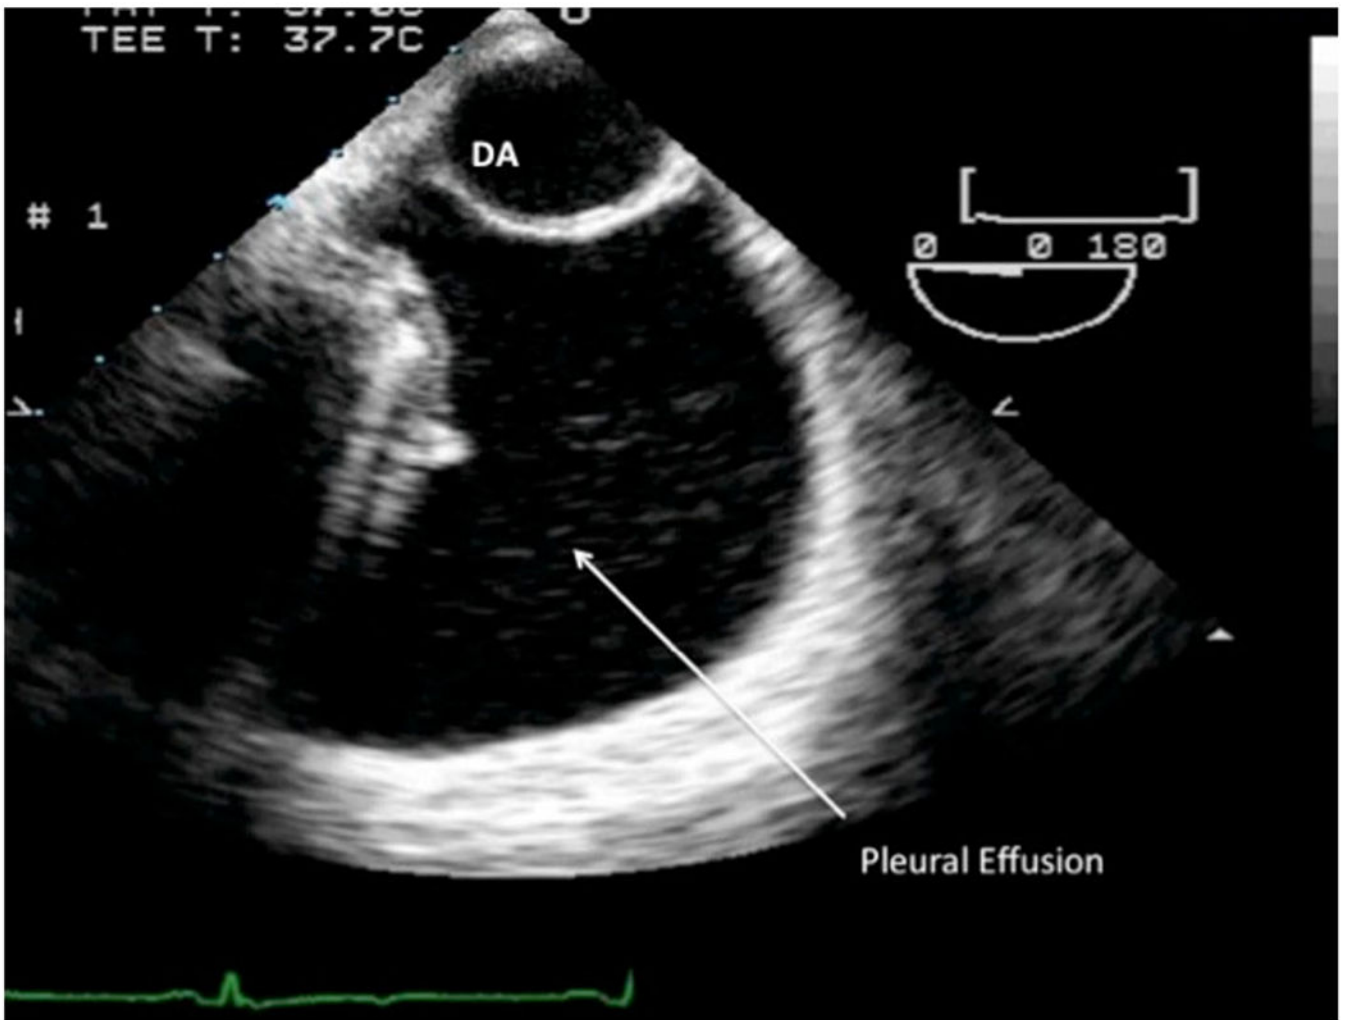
Transesophageal echocardiographic view showing left pleural effusion. Notice the location of the effusion in relation to the descending aorta
